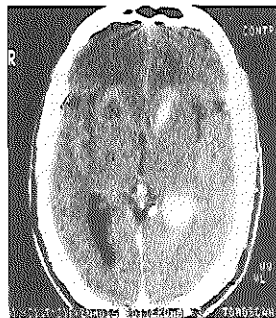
An example of a CT scan of a small lesion with homogenous contrast enhancement. There is only very discrete replacement of midline structures.
